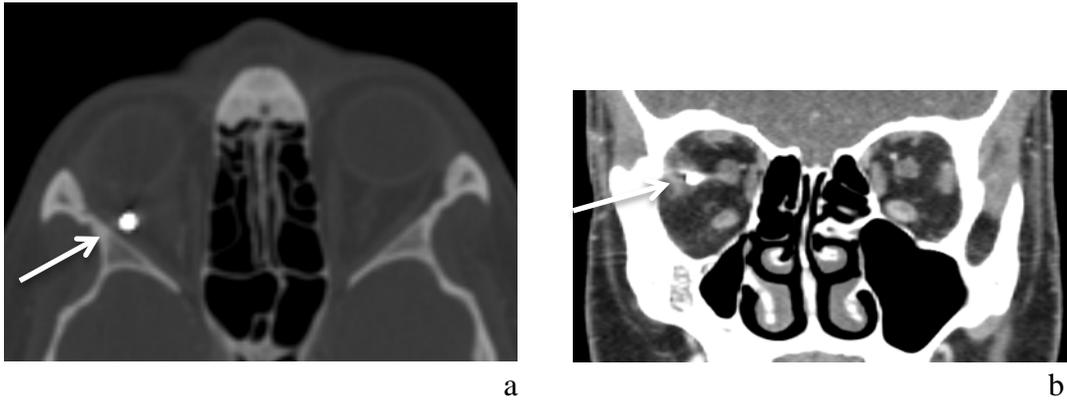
(a/b): Metallic foreign body from a car bomb intramuscularly (27-year-old male with a restriction of movement and a reduced vision of the right eye). CT, axial image (a) and coronal image (b): Metallic foreign body of 4 mm in diameter (white arrow) sticks in right lateral rectus muscle. No osseous fractures.
